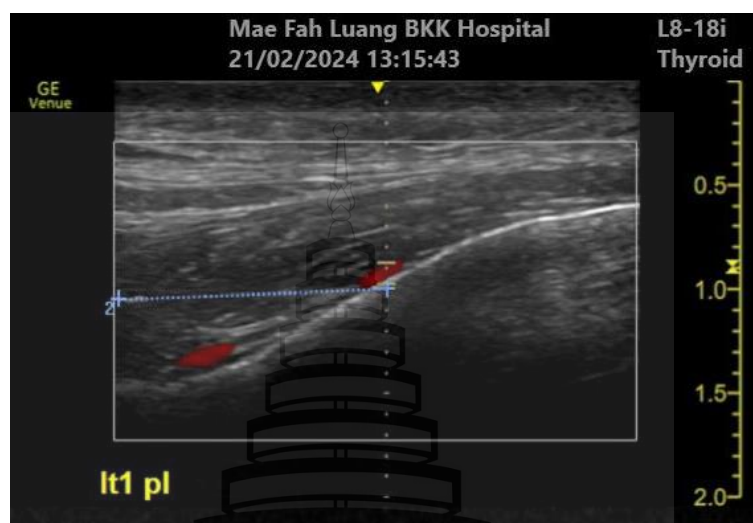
The ultrasound detection at LT1PL found the deep temporal artery at the above the periosteum
